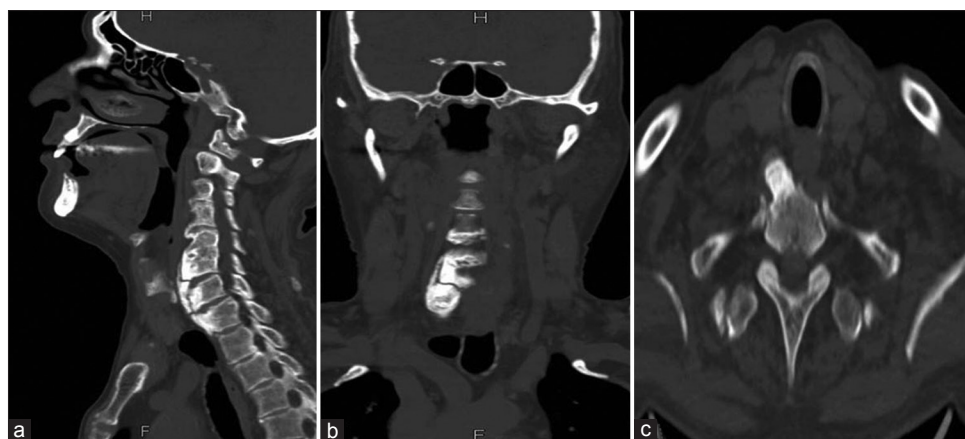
(a) Sagittal, (b) coronal, and (c) axial nonenhanced computed tomography scan images showing right-sided ossified anterior longitudinal ligament extending from C4 to T1. There are also fractures and evidence of pseudo-articulation (arrows). Note the relationship to the thyroid gland and cartilage that lies immediately anterior to the bulky osteophytes
